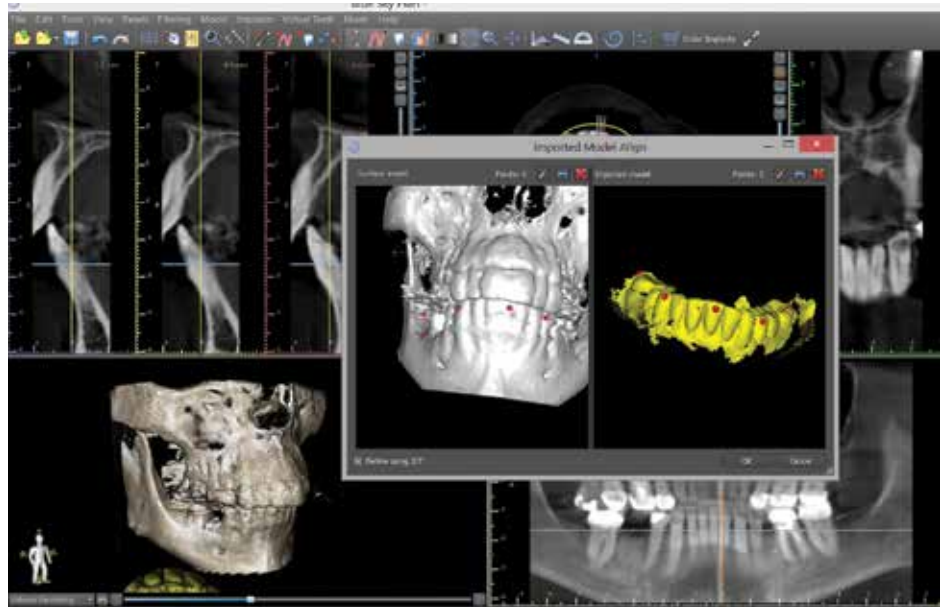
Some software packages allow for the user to superimpose optical images on CBCT scans (Blue Sky Plan, Blue Sky Bio)
